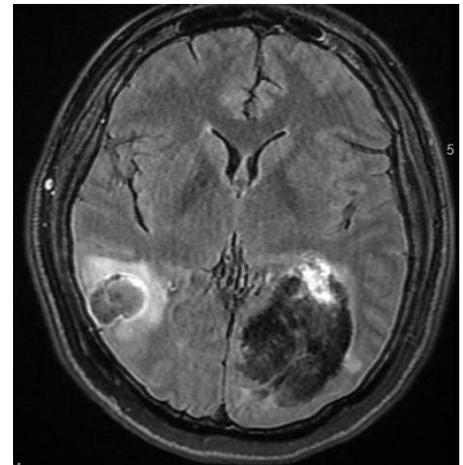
MRI showing brain metastasis causing raised intracranial pressure resulting in abducens nerve palsy.
